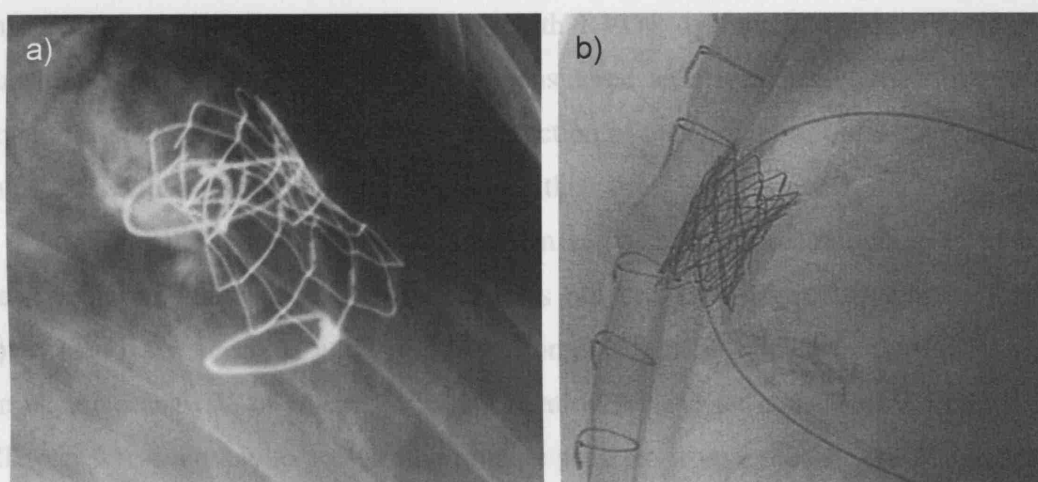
a) X-rays of a patient presented with extensive stent fracture; b) stent-in-stent treatment.
